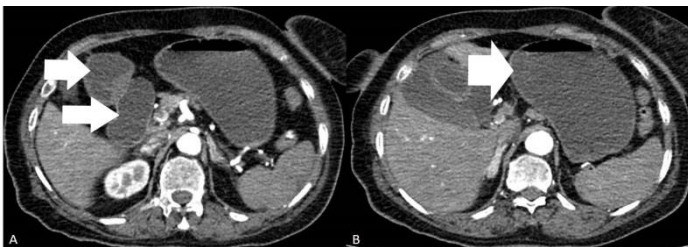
A, B: Contrast enhanced abdominal computed tomography; there are dilated duodenal segments and dilated stomach (arrow)
